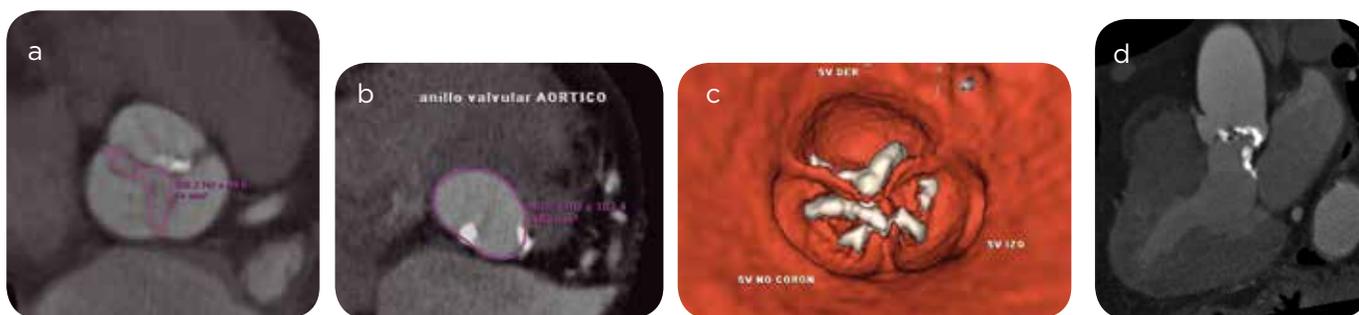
78-year-old patient with severe aortic valve stenosis. Patient in protocol for TAVI planning, cardio-triggered CT, a) orthogonal multi-planar reconstructions of the aortic valve in systole and b) of the valve ring, c) three-dimensional reconstruction with superior sight of the aortic valve in diastole, d) multi-planar reconstruction long axis of three chambers. Anatomically trivalent aortic valve patient, but with complete fusion of the right and left valves, which causes the valve to behave physiologically as a bivalve with semilunar opening in systole (a). A valvular area in systole is identified by planimetry of 0.9 cm<sup>2</sup> that correlates with severe stenosis. The extent of aortic valve calcification is identified through the outflow tract to the base of the anterior valve of the Mitral valve, a finding that must be reported since it significantly increases the risk of perforation in TAVI procedures (d).
